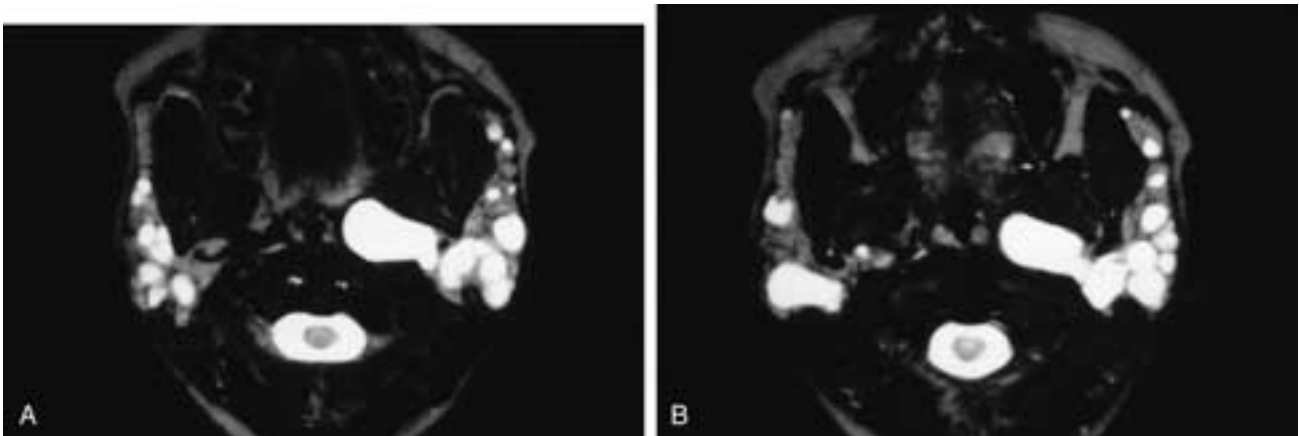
Axial T2-weighted MR images (A, B) show multiple bilateral parotid cysts of varying size. There was no cervical adenopathy. This patient had end-stage cystic changes of autoimmune disease.
